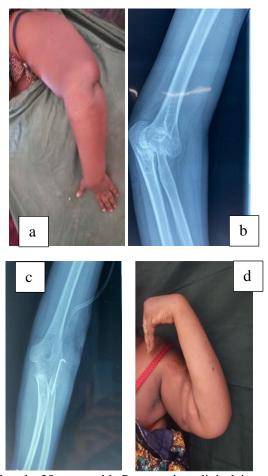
(a): Female 35 years old, Preoperative clinical image; (b): Radiological image showing an old posterolateral dislocation; (c): Frontal elbow control X-ray showing reduction of dislocation reduced and maintained by a pin; (d): Clinical outcome at six months postoperatively, normal elbow flexion.
